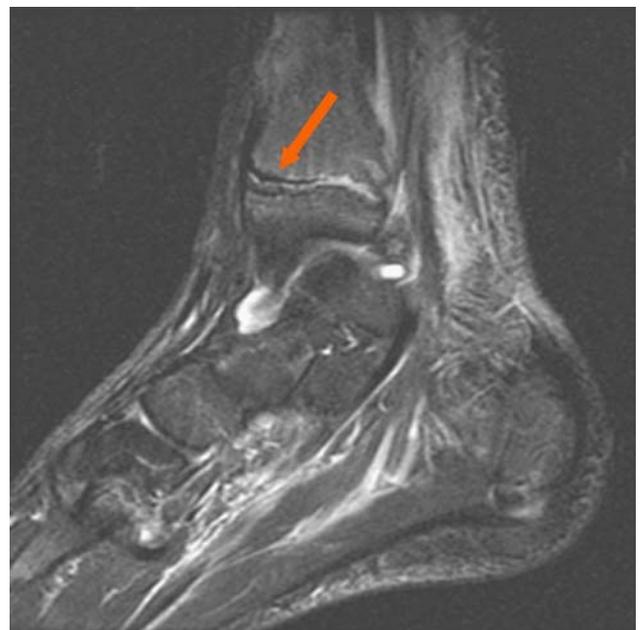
Sagittal T2-weighted image shows the dark signaled periosteum entrapped (red arrow) within the anterior distal tibial physis.
